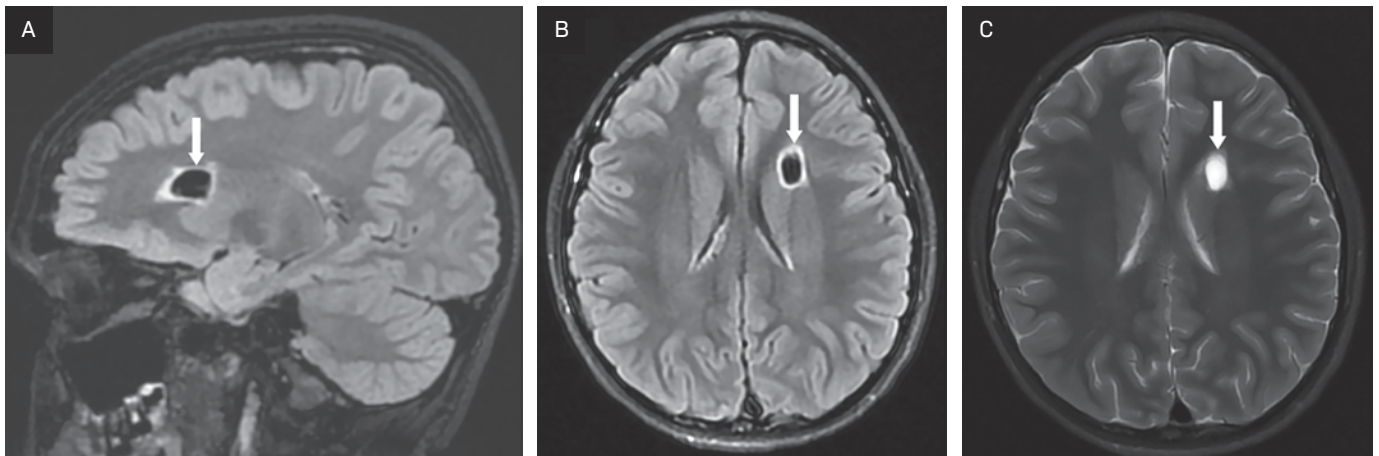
On noncontrast enhanced (A) sagittal and (B) axial T2 FLAIR MRI, the lesion contents are fully suppressed, like CSF, with a border of high-signal (arrow). (C) Noncontrast enhanced T2 PROPELLER fat saturation axial MRI demonstrating normal CSF-like T2 hyperintensity of the cyst contents.
